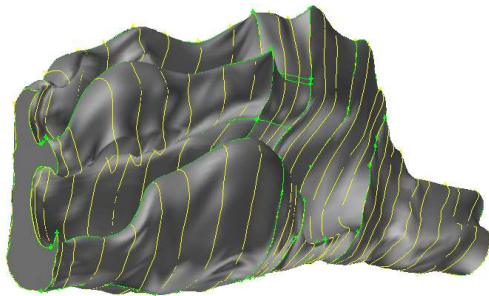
A 3D real-anatomical geometry reconstructed from CT fine-scanned data show the complex boundary details.
